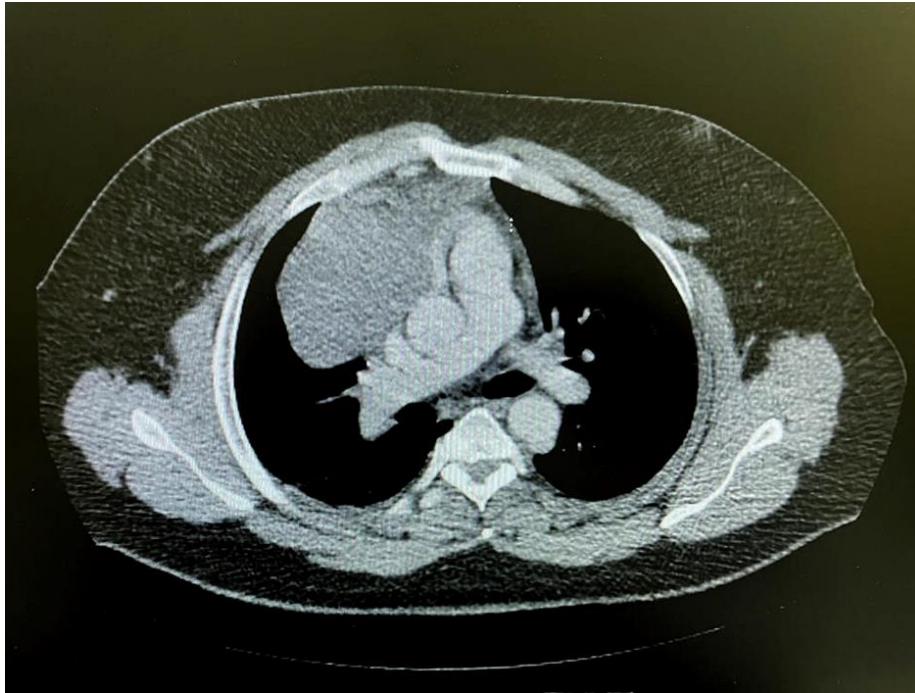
Chest CT performed at the initial visit revealing an 11.0 cm anterior mediastinal mass with mild bilateral pleural effusion.
